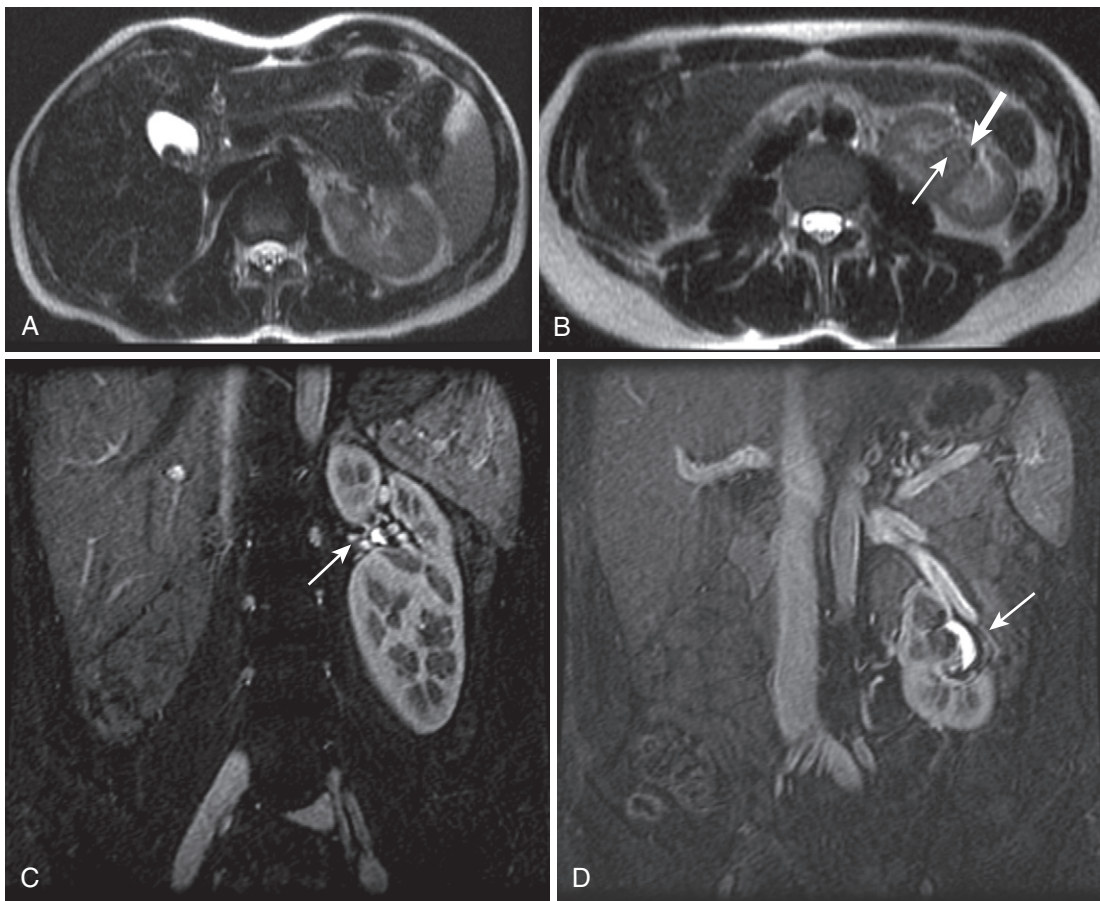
Crossed fused renal ectopia. A, Axial T2-weighted image through the upper abdomen reveals absence of the right kidney. B, More caudally positioned axial T2-weighted image shows orientation of the left lower renal moiety (*thin arrow*) following the expected rotation of the right kidney with the hilum facing laterally (*thick arrow*). C and D, Coronal postcontrast images show the fused conglomerate renal mass with separate hilar structures (*arrow*) and disparate orientation.
